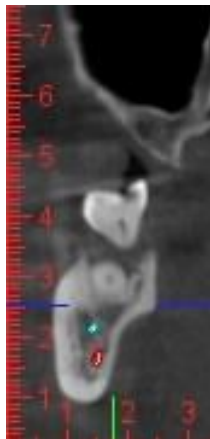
Coronal section of CBCT scan showing relation of first furcation (blue) with the main MC (red).
